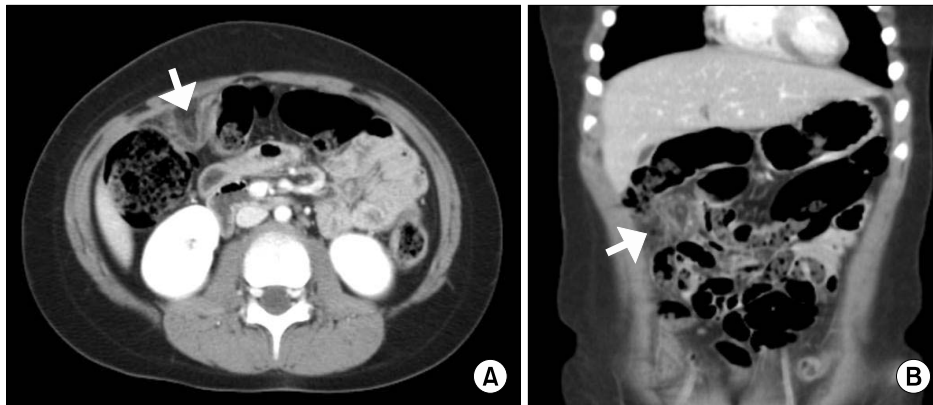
Abdominal computed tomography showing a 2.2-cm ovoid fatty mass surrounded by an enhanced line with minimal haziness observed in the adjacent tissue (arrows): (A) axial views and (B) coronal views.
